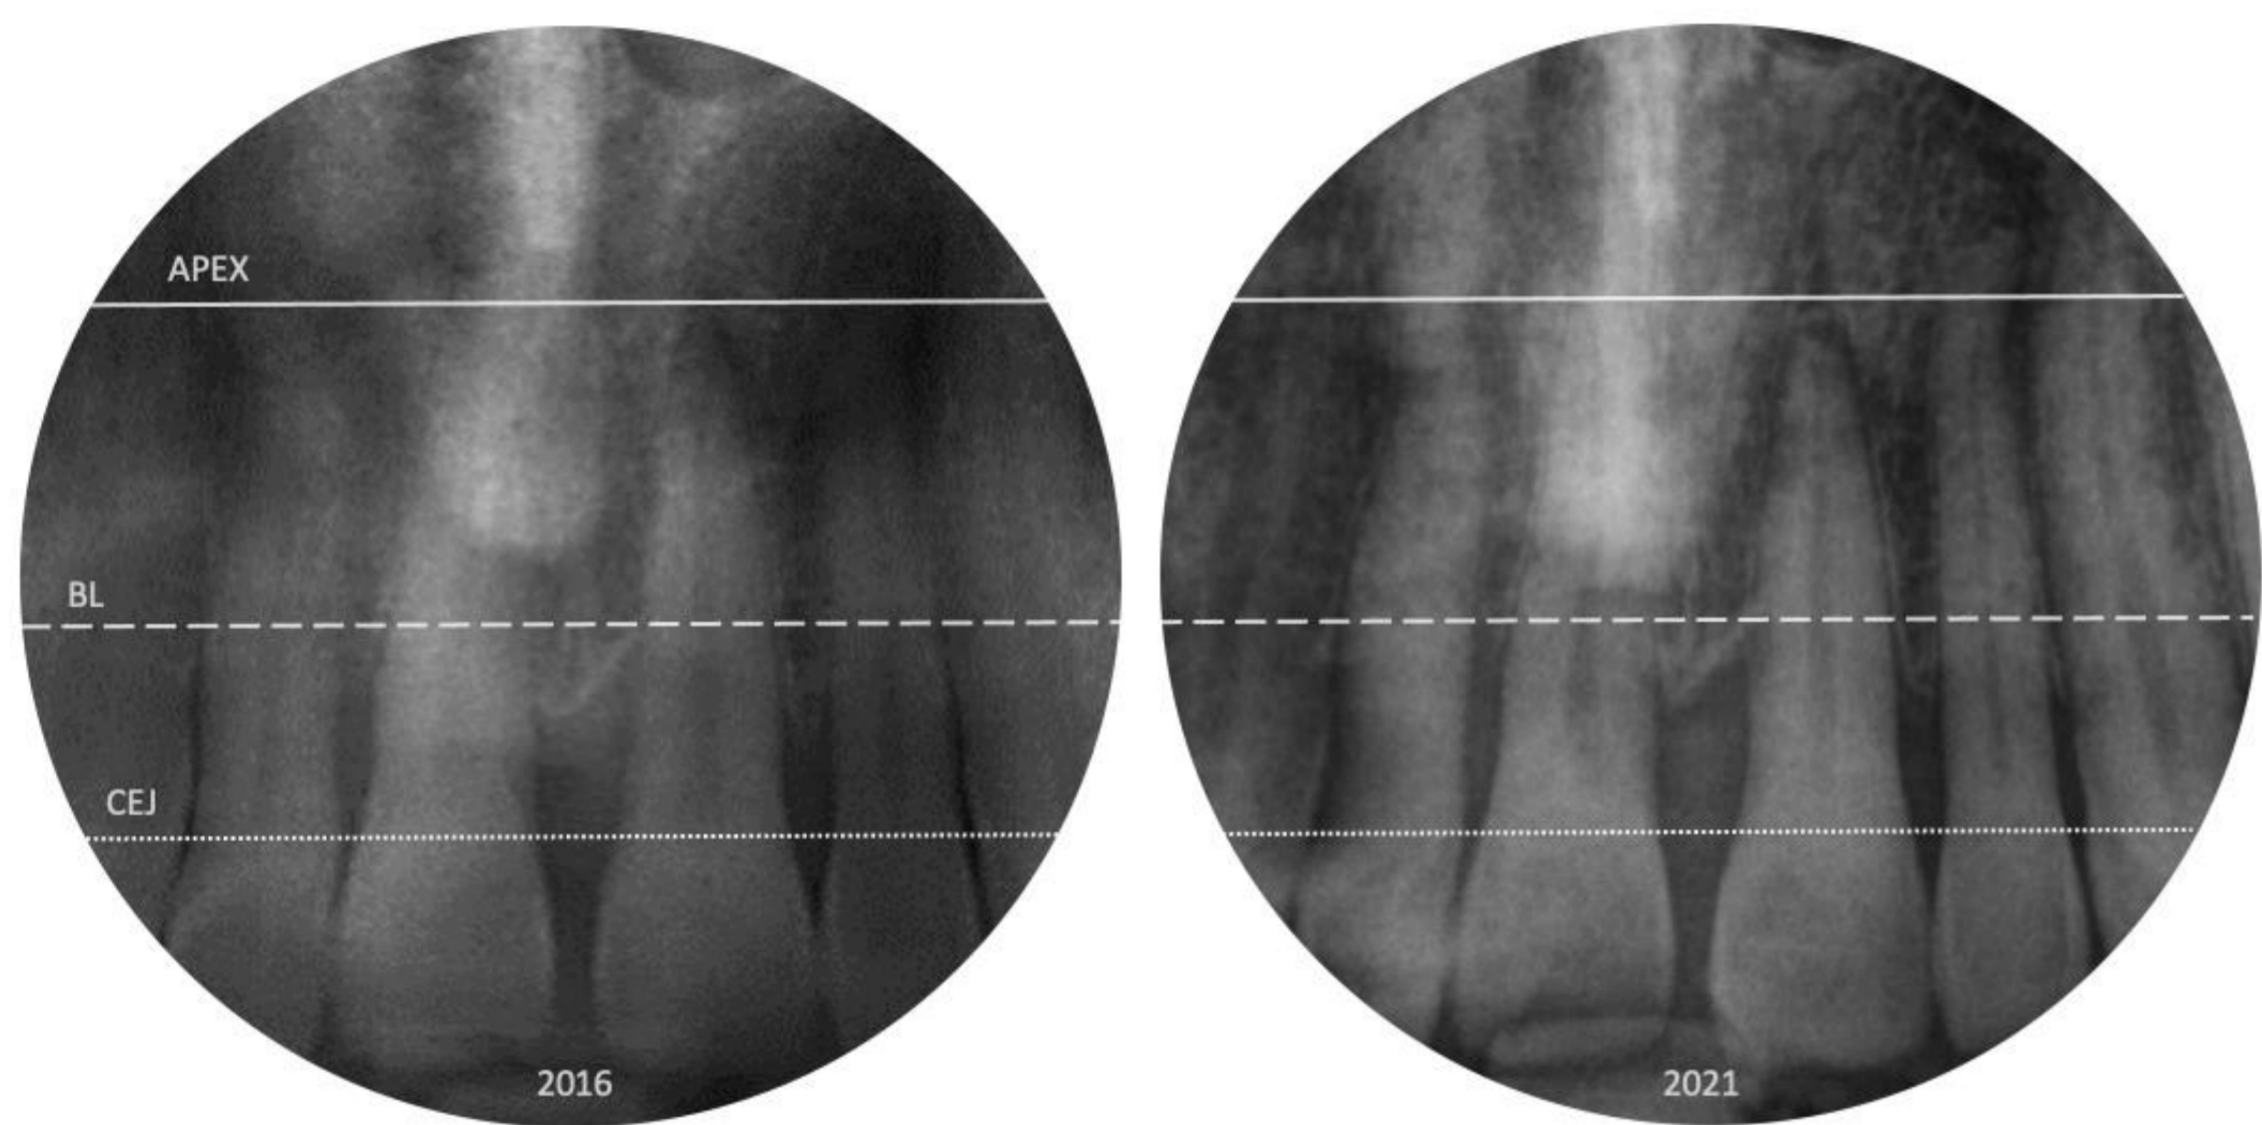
Radiographic measurement of bone loss over 5 years in a 62-year old patient initially classified Grade B using indirect evidence
